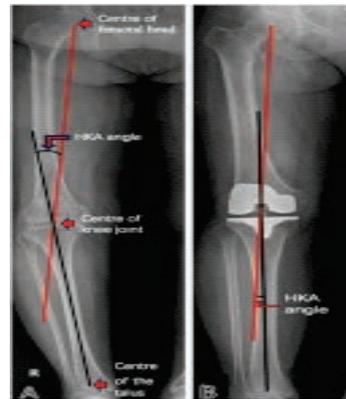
Pre- and Post-Operative X-Rays Showing Hip-Knee-Ankle (HKA) Angle
